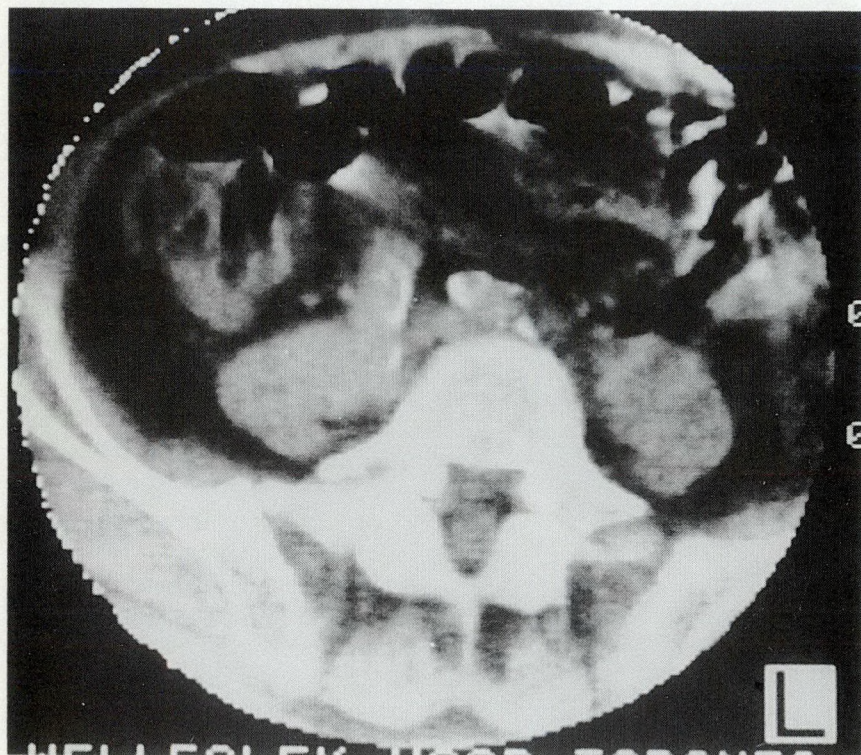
Preoperative computed tomography scan showing ectasia of right common iliac artery.
